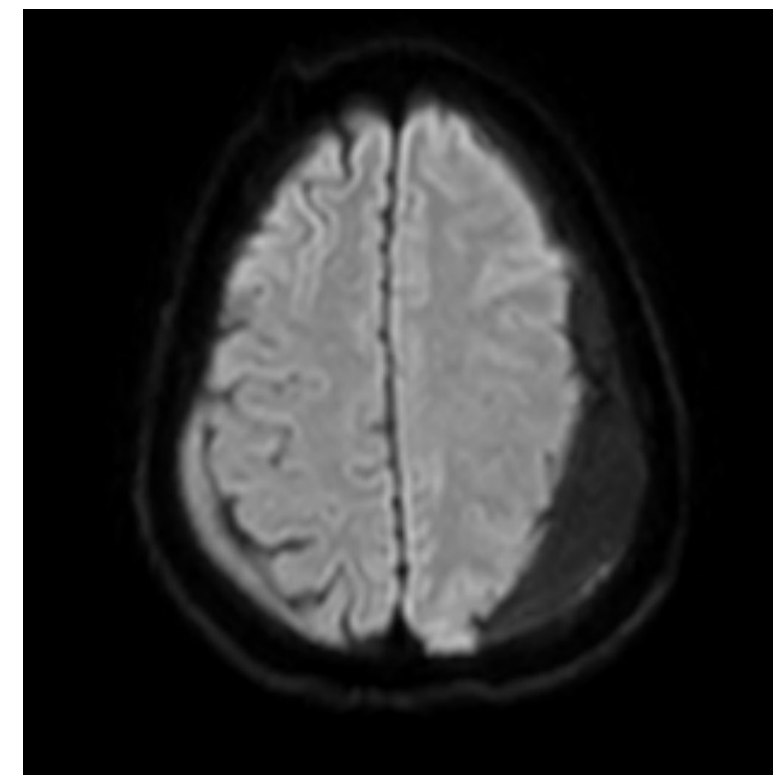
Admission day 2 MRI scan with bilateral hematomas
